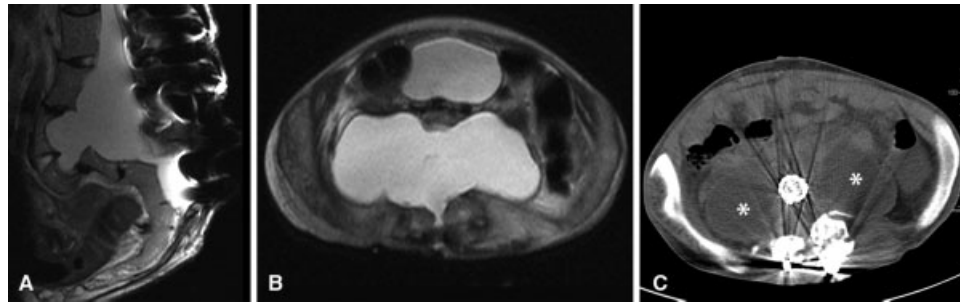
(A) T2-weighted sagittal and (B) transversal magnetic resonance imaging reveals deformity of the lumbar spine and the extensive meningocele that is partially filling the lesser pelvis. (C) Axial computed tomography scan after the final operation reveals persistence of the lateral parts of the cele (asterisks) whereas the median parts had been gathered.
